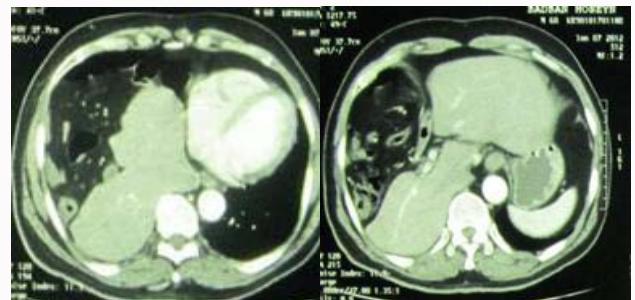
CT-scan show herniated and vertically position of liver with displacement of mediastinum and heart, and show omentum and colon.
